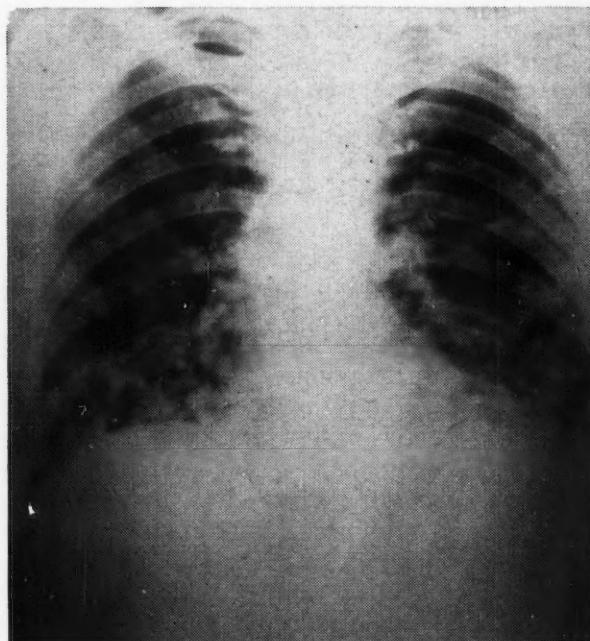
Chest radiograph of 1935 showing peculiar mottling of the lung fields. Films in 1946 and 1956 showed no further change.
